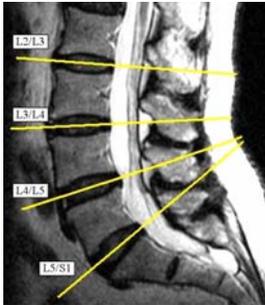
Sagittal T2-weighted MR image of the lumbar spine showing levels at which the paravertebral muscle cross-sectional area was measured.
